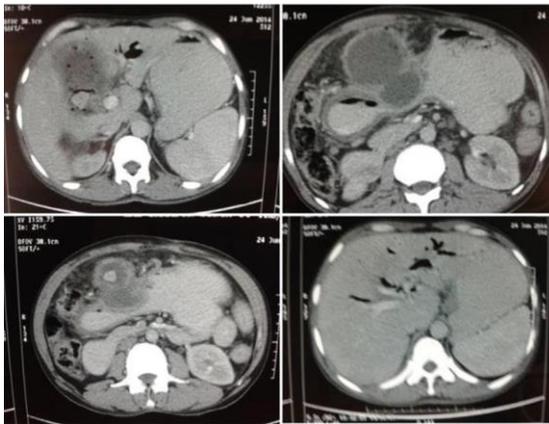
(A) Axial CT scan shows multiple air foci within distended GB along with calculi, pneumobilia and distended stomach; (B) Axial CT scan shows fistula between duodenum and gallbladder with air foci within it and distended stomach; (C) Axial CT scan shows fistula between duodenum and GB with calculus; (D) Axial CT scan shows pneumobilia within biliary radicles of liver
